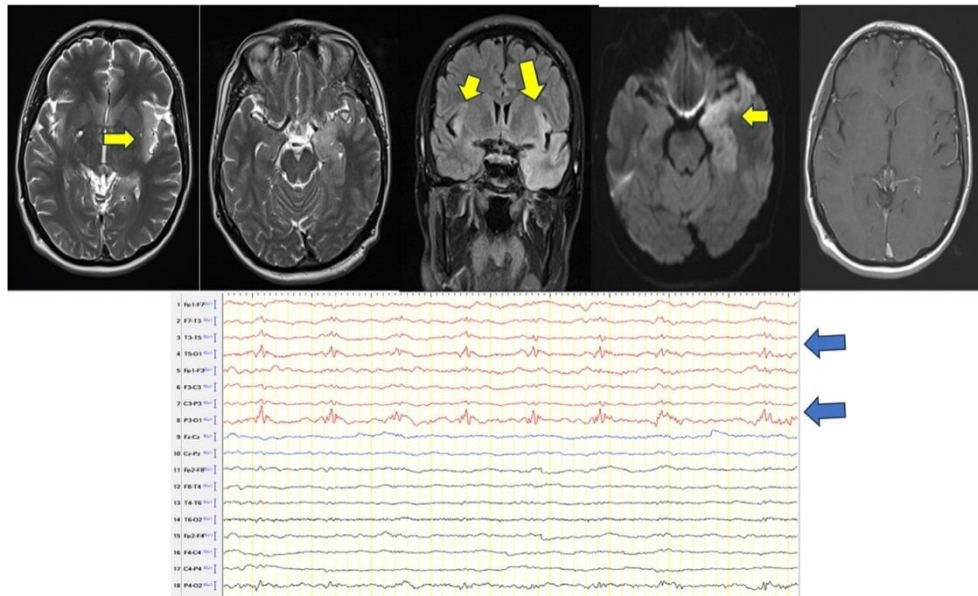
Cranial MRI and EEG examinations of the first case at the time of presentation. MRI demonstrated an asymmetric hyperintense lesion in the left medial temporal lobe, hippocampal region, and insular cortex (yellow arrows). EEG showed lateralized periodic discharges with sharp and spike-wave activities of high amplitude in the left temporoparietal region (blue arrows).
